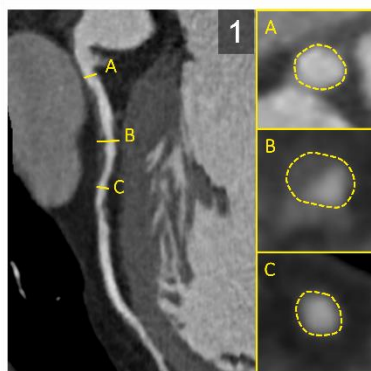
Noncalcified coronary plaques on CTA on a curved multiplanar reformation and cross-sections.
